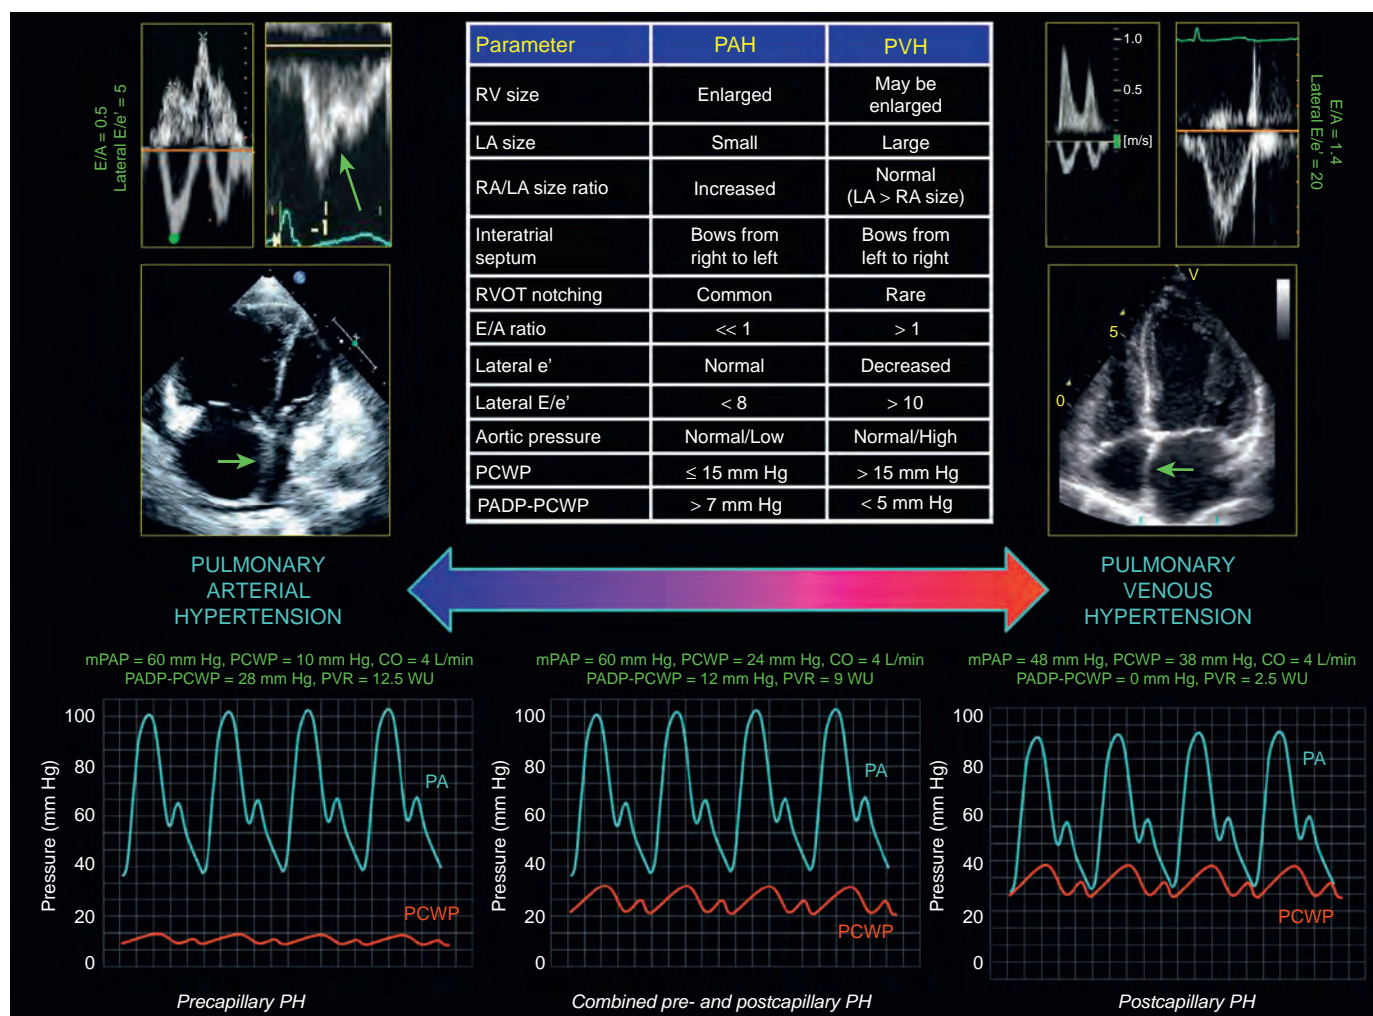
Left, Prototypical echocardiographic and invasive hemodynamic findings from a patient with pulmonary arterial hypertension (PAH). The right atrium and right ventricle are severely enlarged, and the left ventricle and left atrium are small and underfilled. The interatrial septum bows from right to left. On mitral inflow, the E/A ratio (ratio of early to late (atrial) mitral inflow velocities) is less than 1 because of underfilling of the left atrium and decreased compliance of the left ventricle secondary to extrinsic compression from the enlarged right ventricle. The lateral e' velocity and lateral E/e' ratio (ratio of early mitral inflow velocity to early diastolic mitral annular tissue velocity) are normal (<8), suggesting normal left ventricular (LV) relaxation and filling pressures. Notching is noted in the right ventricular (RV) outflow tract (RVOT) profile on pulse-wave Doppler imaging because of increased pulmonary artery (PA) stiffness. The pulmonary capillary wedge pressure (PCWP) is normal, and the pulmonary artery diastolic pressure (PADP)-PCWP gradient is severely increased. Right, Prototypical echocardiographic and invasive hemodynamic findings from a patient with pulmonary venous hypertension (PVH). The left atrium is enlarged, and the interatrial septum bows from left to right. On mitral inflow, the E/A ratio is greater than 1, the lateral e' velocity is reduced, and lateral E/e' ratio is increased, suggestive of grade 2 diastolic dysfunction with impaired LV relaxation and elevated LV filling pressures. No notching is noted in the RVOT profile. The PCWP is elevated, and no gradient is present between the PADP and the PCWP. Although the right ventricle in the right panel is not enlarged, RV enlargement and dysfunction can be present in patients with isolated PVH. Upper middle, Parameters helpful for differentiating PAH from PVH on echocardiography and invasive hemodynamic testing. Lower middle, Invasive hemodynamic findings in a patient with combined precapillary and postcapillary pulmonary hypertension (PH) (elevated PCWP and PADP-PCWP gradient). The most challenging patients are in this middle zone (combined precapillary and postcapillary PH), with echocardiographic findings that lie in the middle of the prototypical examples of PAH and PVH shown here. In these patients, careful evaluation of the echocardiogram and invasive hemodynamics will be necessary for an accurate diagnosis. CO, Cardiac output; LA, left atrial; mPAP, mean pulmonary arterial pressure; PVR, pulmonary vascular resistance; RA, right atrial. (Reprinted with permission from Vallerie V, McLaughlin V, Shah S, et al. Management of pulmonary arterial hypertension. J Am Coll Cardiol. 2015;65: 1976–1997.)
